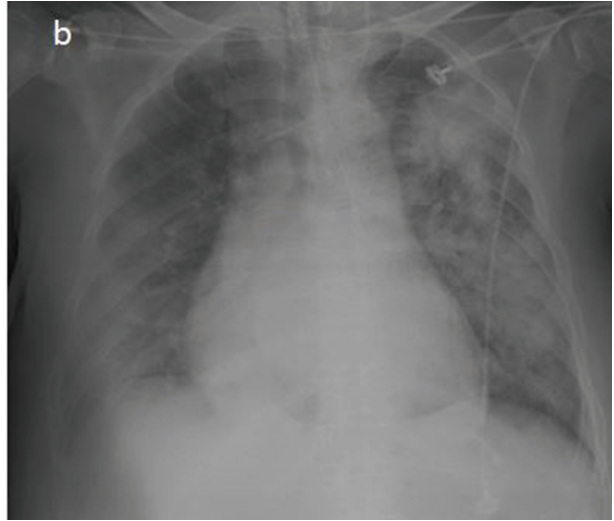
Chest X-ray before ECMO on day 6.
